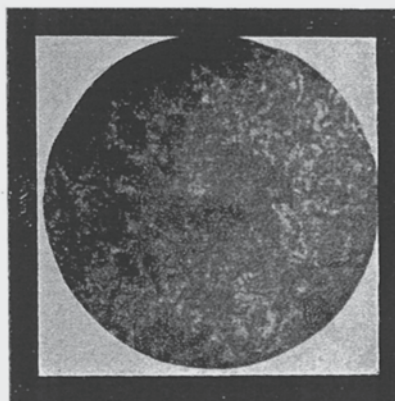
Même malade. Radiographie de contact avec cône rétréci mettant en évidence les innombrables calcifications en grain de sel de type malin dans le noyau tumoral.
